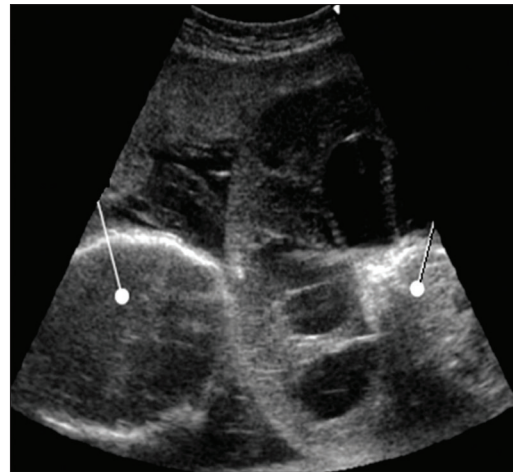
Ultrasound taken at 20 weeks of gestation showing pump twin and acardiac twin.
